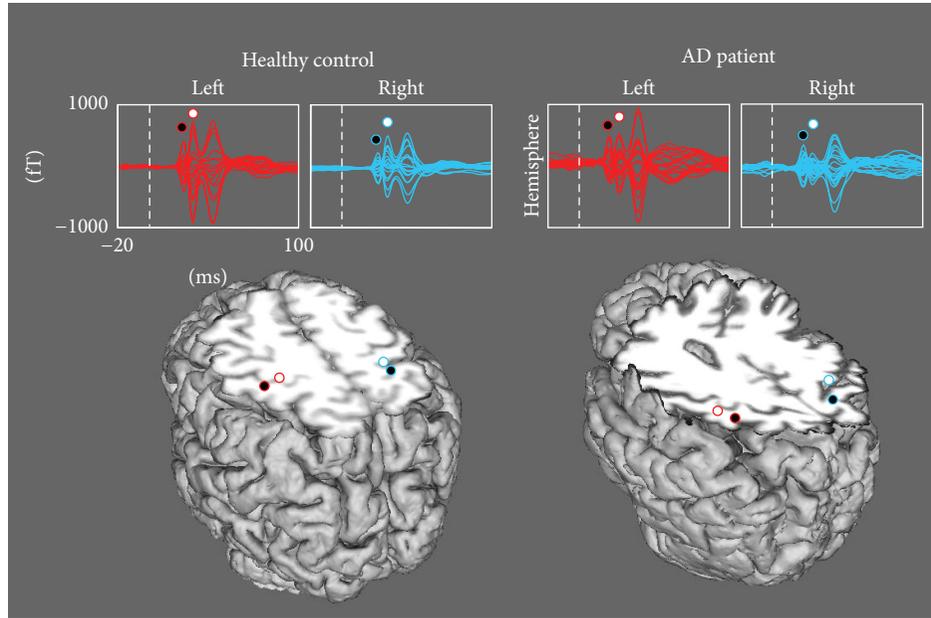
SEF and M20 and M30 ECD positions in a representative healthy control (F , 68 y.o., MMSE = 29) and an AD patient (F , 63 y.o., MMSE = 24). (Top) superimposition of all channels in the rolandic region, averaged in the $[-20, 100]$ ms period, 0 representing the time of stimulus delivery. The amplitude of the magnetic field is represented in femtotesla (fT) on the y -axis; (Bottom) positions of the ECDs explaining the cerebral activation in correspondence to the M20 (black circle) and M30 (white circle) components, projected onto a suitable axial slice after volumetric head reconstruction from individual MR images.
